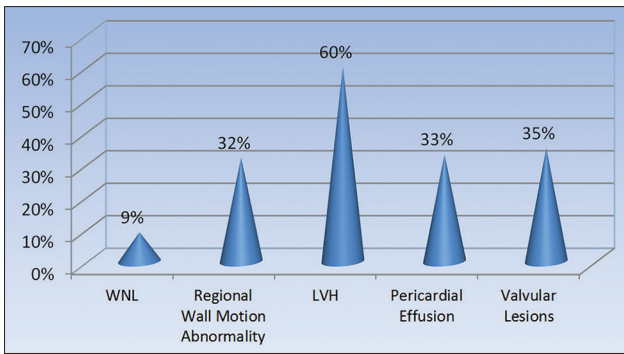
Echocardiographic finding of studied cases
